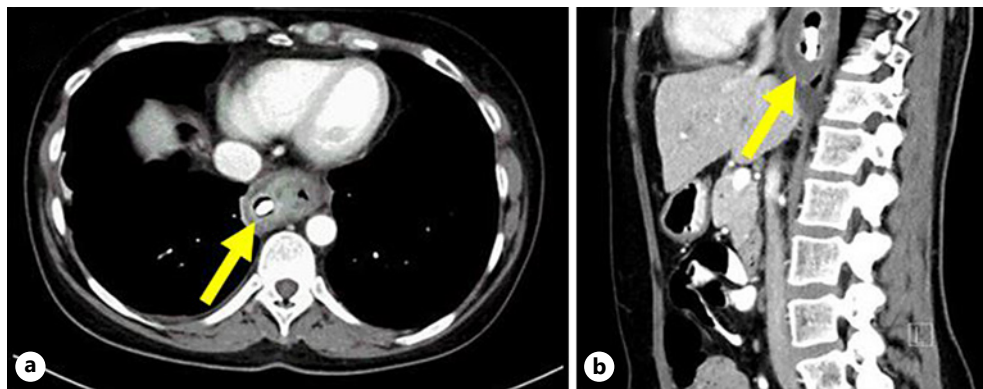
Computed tomography chest with contrast (A, transversal view B, sagittal view). A radio-opaque object (arrow) is seen in the posterior right mediastinum, with a small amount of adjacent fluid and marked surrounding inflammatory changes. No gas is present within the collection. A small right-sided pleural effusion is noted.
